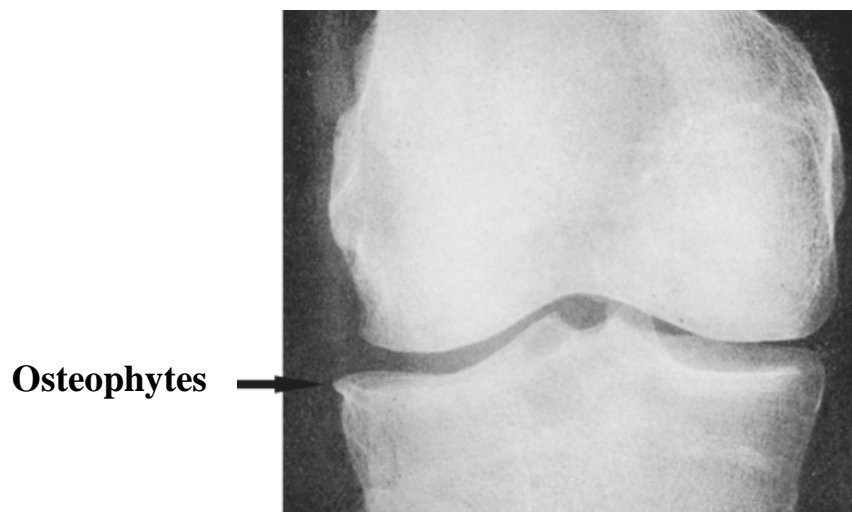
Radiographic osteophytes
